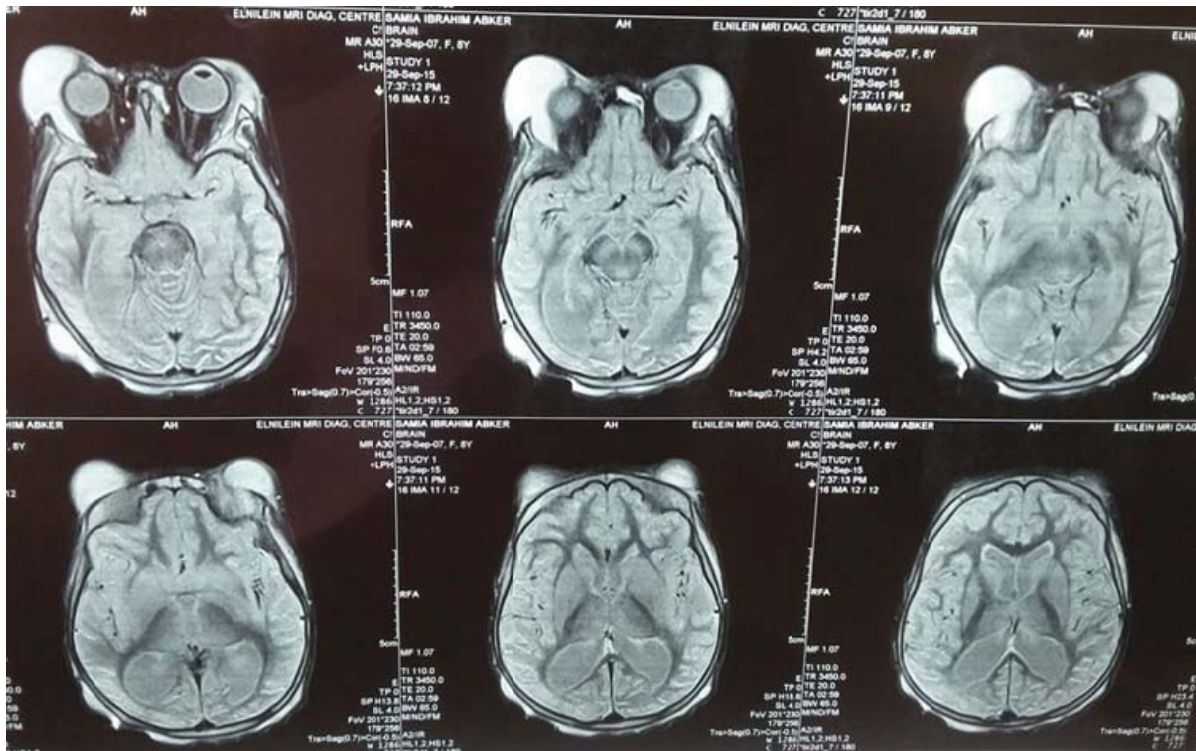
Brain MRI displayed: Axial T1W1 and coronal T1W1 reveals well defined mass lesions with iso-intense signals intensity and include hyper-intense areas. Axial and coronal T2W1 and FLAIR shows the mass lesions with high signals representing eyelid edema with pocket collection of portentous material (sub-acute hematoma). The mass seen arise from the roof of the orbital wall extending laterally intra-orbital affecting both orbits, pushing, displacing and compressing the eye globes medially and anteriorly causing proptosis (RT 3.5x2.3 cm)(LT 2.3x1.5 cm).
